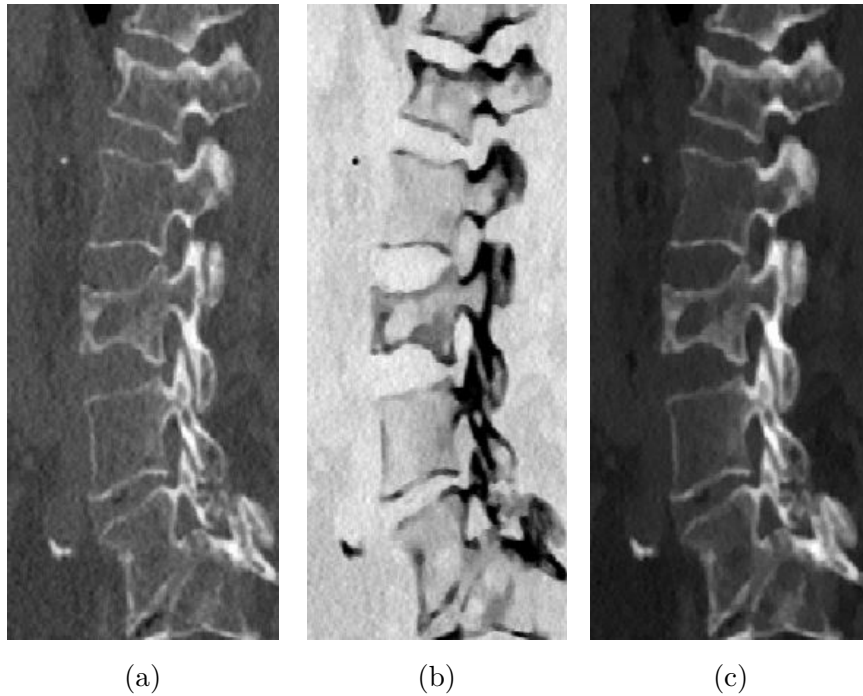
Example of different types of images, multiple myeloma patient, (a) - conventional CT, (b) calcium suppress at 25 %, (c) - virtual monoenergetic image at 40 keV.
